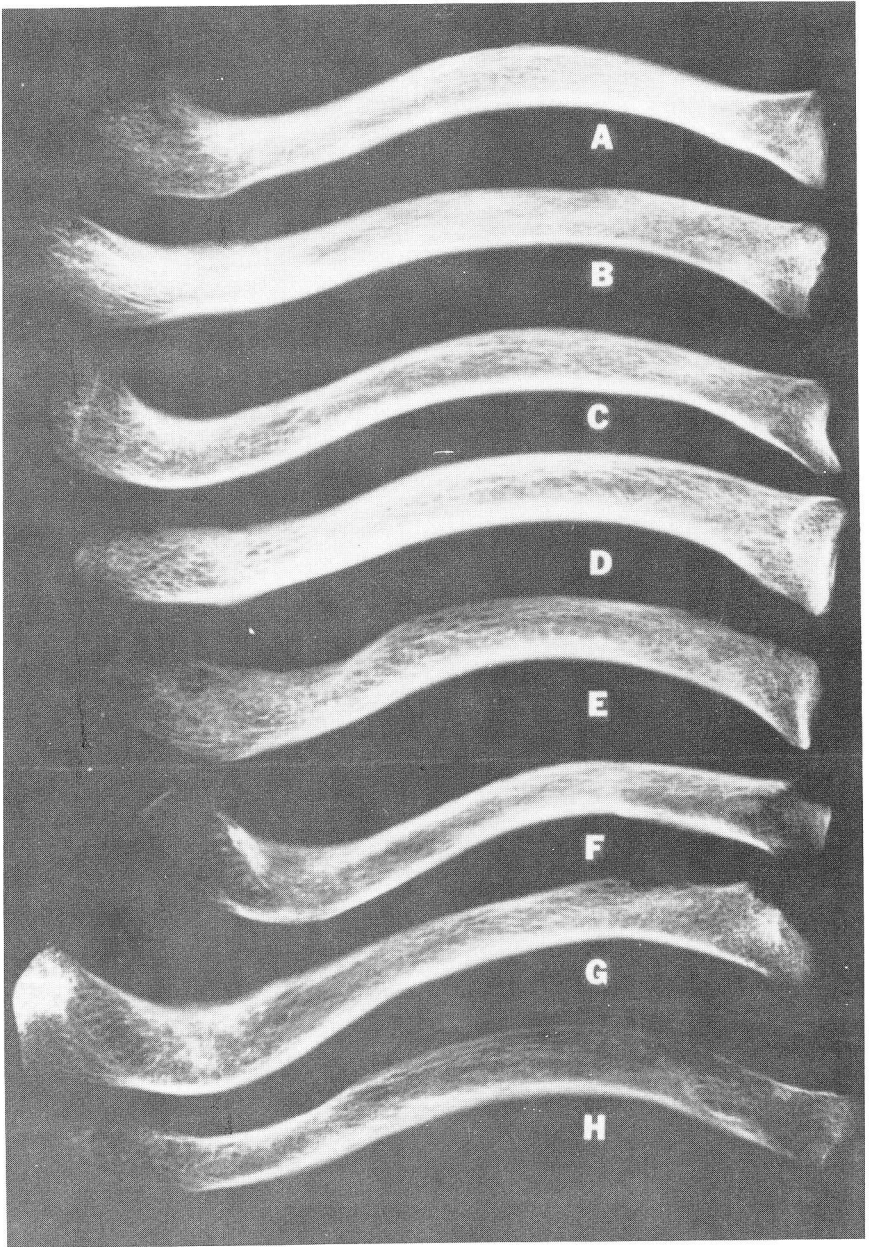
Radiographic standards for seriation of the clavicle. (A) Phase 1, 18–24 years, (B) Phase 1, 25–29 years, (C) Phase 1, 30–34 years, (D) Phase 1, 35–39 years, (E) Phase 1, 40–44 years, (F) Phase 1, 45–49 years, (G) Phase 1, 50–54 years, (H) Phase 1, 55+ years (Walker and Lovejoy, '85).
